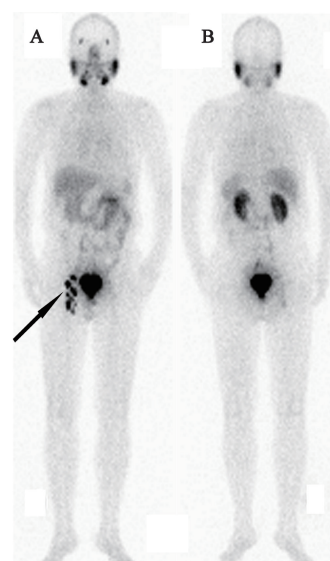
^{99m}Tc -PSMA静脉注射后2 h全身平面显像
